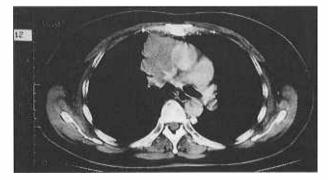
CT scan thorax at presentation showing an irregular mass in the right middle lobe with bilateral hilar lymphadenopathy.
